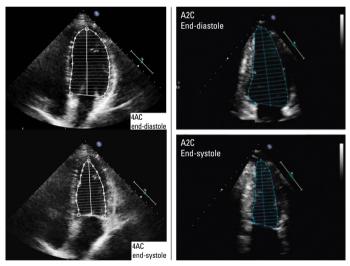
Two-dimensional measurements of left ventricle (LV) volumes using the biplane method of discs (modified Simpson's rule), in the apical four-chamber (A4C) and the apical two-chamber (A2C) views at end-diastole (LVEDV) and at end-systole (LVESV). LV trabeculations and the papillary muscles should be excluded from the cavity in the tracing
